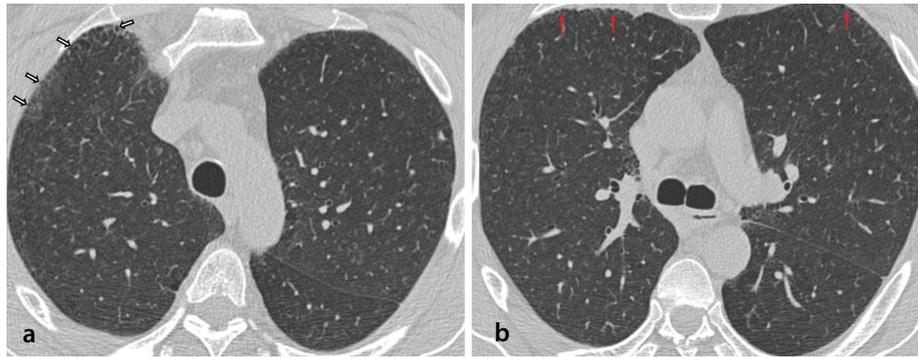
Respiratory bronchiolitis-interstitial lung disease (RB-ILD) pattern on chest computed tomography (CT). Axial CT images (a, b) demonstrate ill-defined centrilobular nodules and patchy, mild ground-glass opacities with upper-lobe predominance, representing the key imaging features of RB-ILD. Associated paraseptal emphysema is present (red arrows), consistent with a smoking-related ILD. Minimal subpleural reticulation and bronchiolectasis (white arrows) are incidental but are not defining features of RB-ILD.
